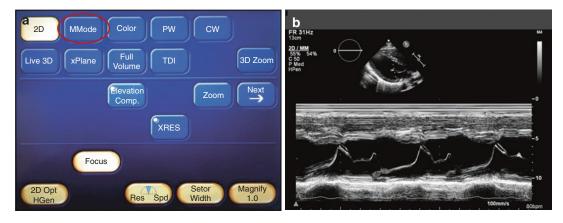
(a) The digital panel indicating the digital button to switch to M-mode imaging (*red circle*). (b) Parasternal long-axis M-mode imaging of mitral valve
